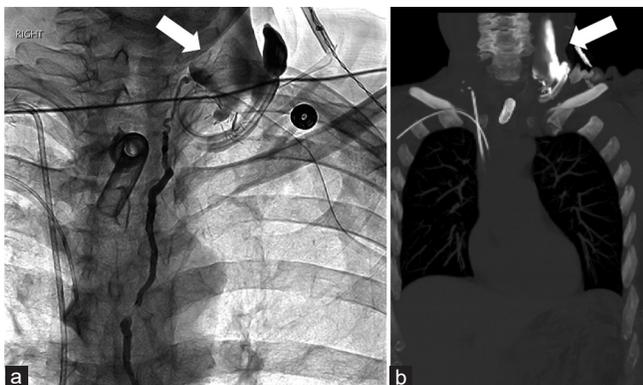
(a) Fluoroscopy identifies active contrast leakage (arrow) within the cervical thoracic duct with adjacent postsurgical changes. (b) Coronal angiography/computed tomography shows contrast extravasation in the same region of the left neck (arrow), confirming diagnosis of iatrogenic thoracic duct transection
